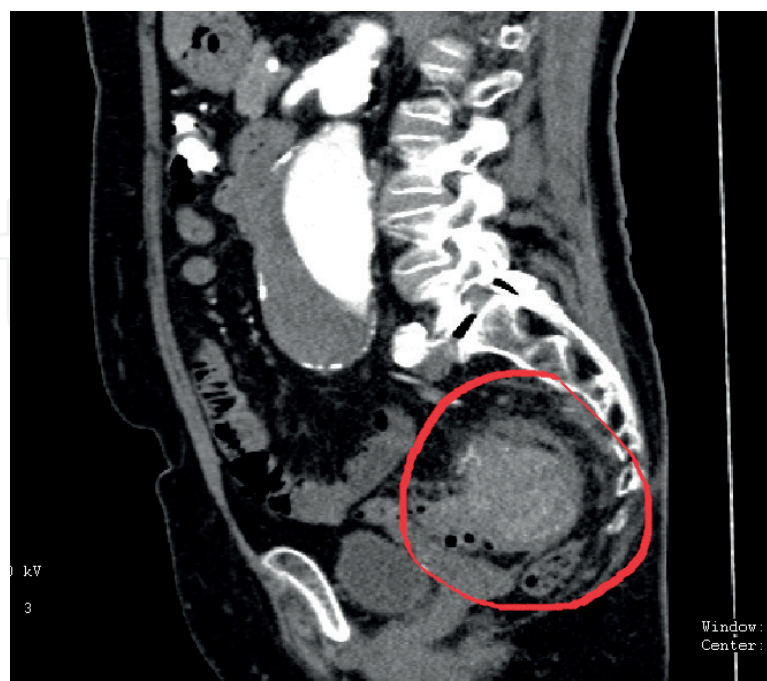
AAA and rectosigmoid tumor (CTA).
